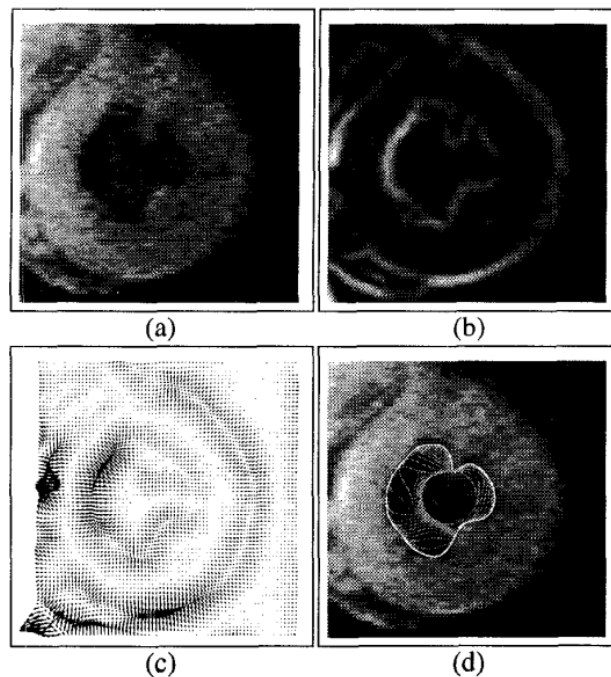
Whole process of application of GVF as external force for active contour segmentation of a medical image. (a) MRI of the left ventricle of a human heart(a). (b)- the edge mapping function $f(x,y)$, with $\sigma=2.5$. (c)- GVF of image. (d)- Left ventricle segmentation shown as a white curve [60].
